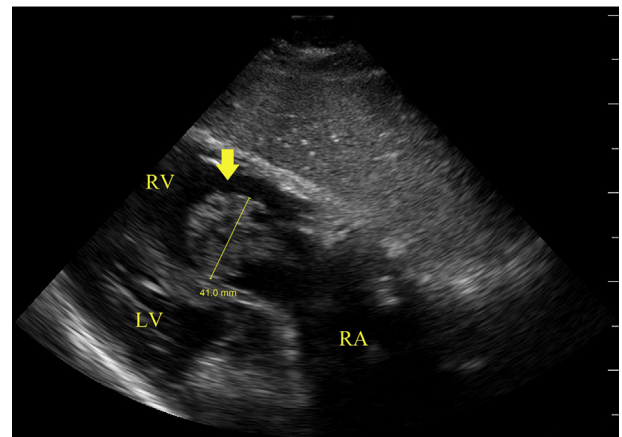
Subcostal view on transthoracic POCUS demonstrates a large echodensity traversing the tricuspid valve (yellow arrow). *LV*, Left ventricle; *RA*, right atrium; *RV*, right ventricle.
